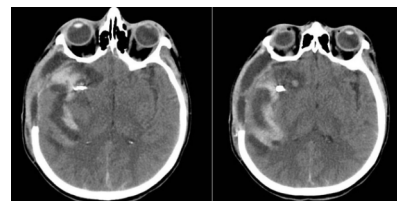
a, b Postoperative axial noncontrast-enhanced computed tomography (CT) shows status after clip occlusion of MCA aneurysm linked with enormous brain edema, (Department of Radiology, Clinical Center University of Sarajevo 2016)
